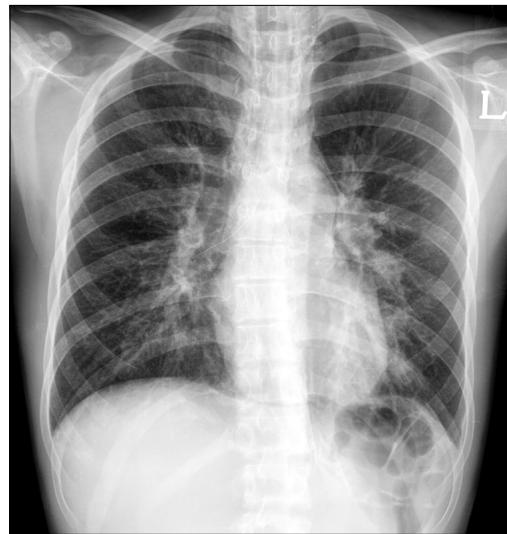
Chest radiograph revealing air streaks in the mediastinum.
